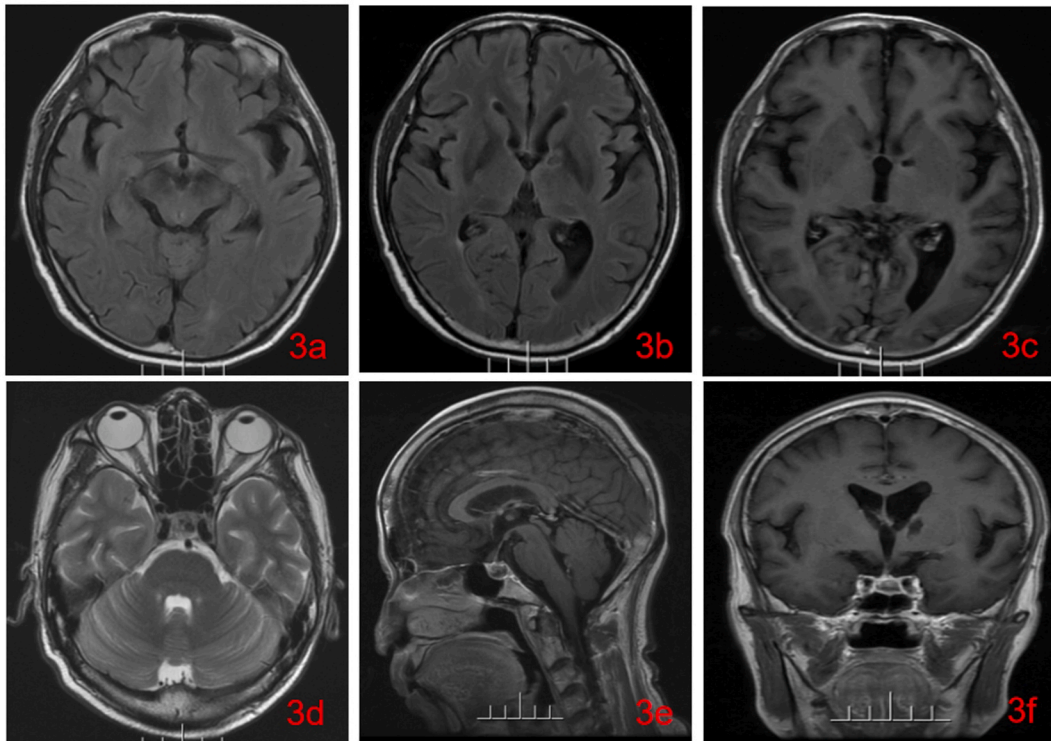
MRI 1 month following treatment initiation, axial T2/FLAIR showing hyperintensity of the optic tract, a low signal intensity inner and a high signal intensity outer of the left basal ganglia (3a, 3b). Enhanced axial T1W demonstrating no longer contrast enhancement in the left basal ganglia and leptomeninges (3c). Axial T2W showing a circular asymmetry density in the sella turcica and suprasellar region (3d). Enhanced sagittal T1W and enhanced coronal T1W demonstrating a ring-like enhancement in the sella turcica and suprasellar region (3e, 3f). All imaging changes (3a-3f) demonstrate additional improvement compared to the previous study.
